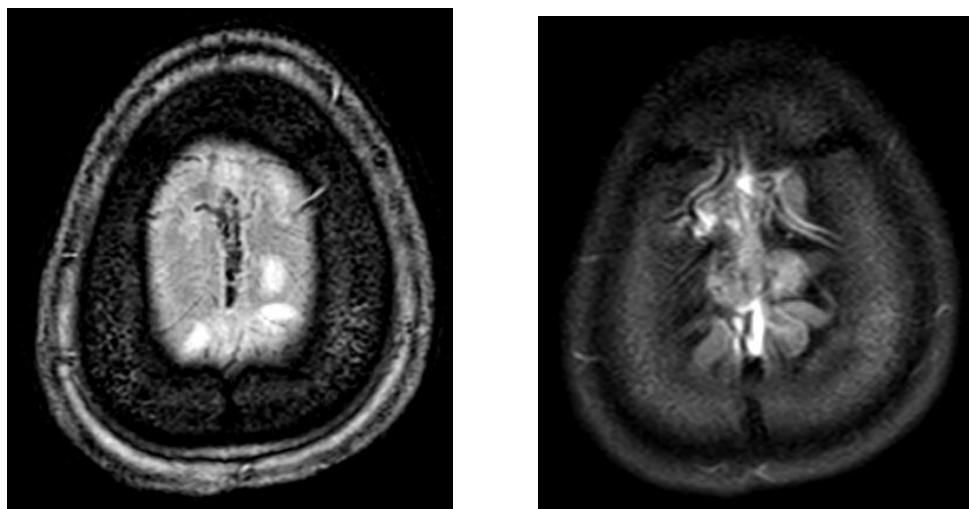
a) SWI image in a patient presenting with headache showing blooming in the superior sagittal sinus b) Phase Contrast MR image axial section in the same patient showing non opacification in the superior sagittal sinus confirming thrombosis
